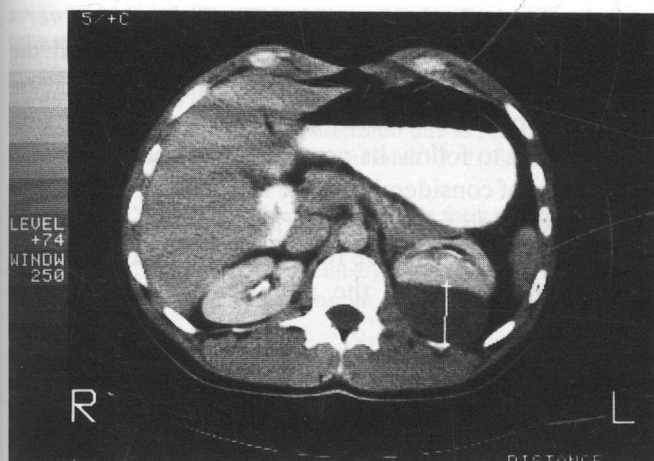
CT shows compression of the renal parenchyma by an elliptically shaped (6.6×3.5 cm in diameter), low-density (+10 HU) fluid collection lying lateral and posterior to the left kidney and confined by the perirenal fascia.
